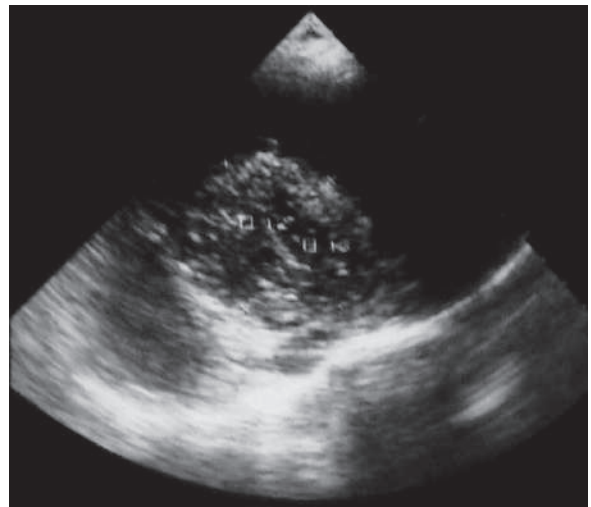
Ultrasound image of a liver hydatid cyst shows internal, multiple, solid-like lesions within the cyst (ball of wool sign)
